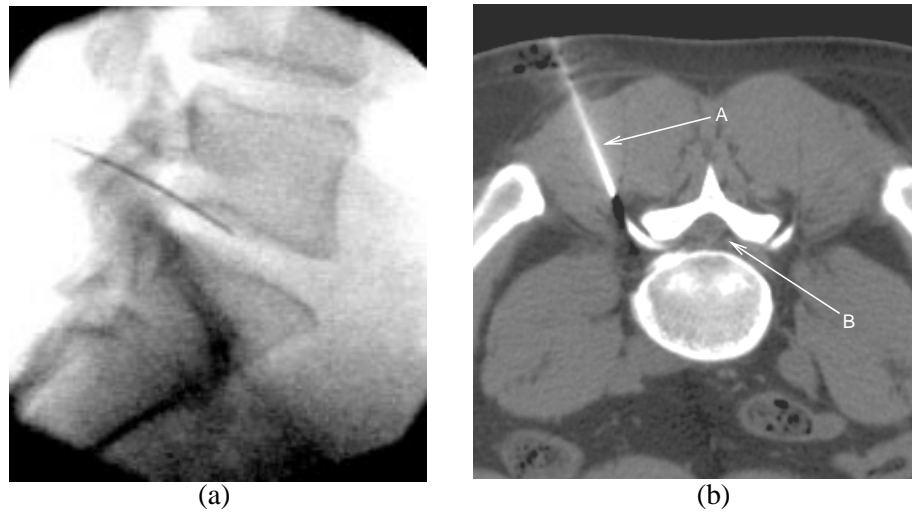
Images from a percutaneous laser nucleotomy procedure, (a) interventional fluoroscopy image showing 2D position of needle, (b) axial slice from an interventional CT volume showing (A) 3D position of needle and (B) root of first sacral nerve.
